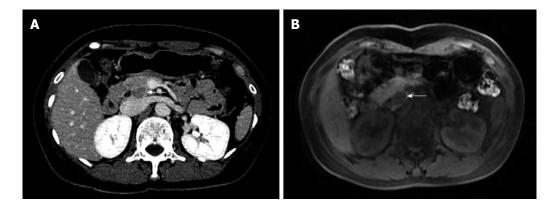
Abdomen computed tomography-scan. A: CT delayed phase: a relatively low density of nodules (arrow) of approximately 1 cm × 1.4 cm in the uncus of the pancreas; B: Round abnormal signal (arrow) of 1.7 cm × 1.4 cm was found in the head and uncus of the pancreas, T1WI showed low signal, clearly contrasting with normal pancreatic tissue surrounding a relatively high signal.
